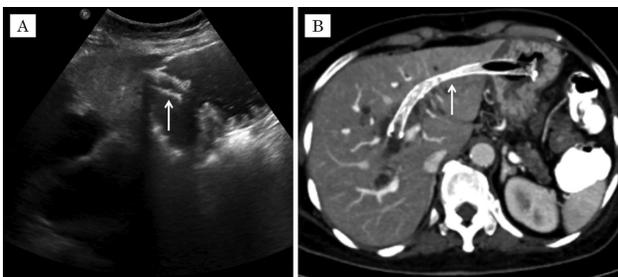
Immediate postprocedure transabdominal ultrasound image (A) showing one of the ends of the stent within the gastric lumen (solid arrow). Axial image from the follow-up computed tomographic image (B) showing the stent (solid arrow) optimally placed in situ.
